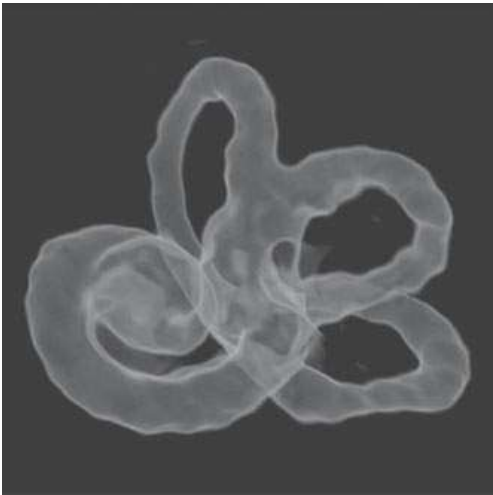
Three-dimensional computed tomography reconstruction of the cochleovestibular system. The semicircular canals are positioned orthogonal to one another and show enlargement at their entrance into the vestibule (ampullary ends).
